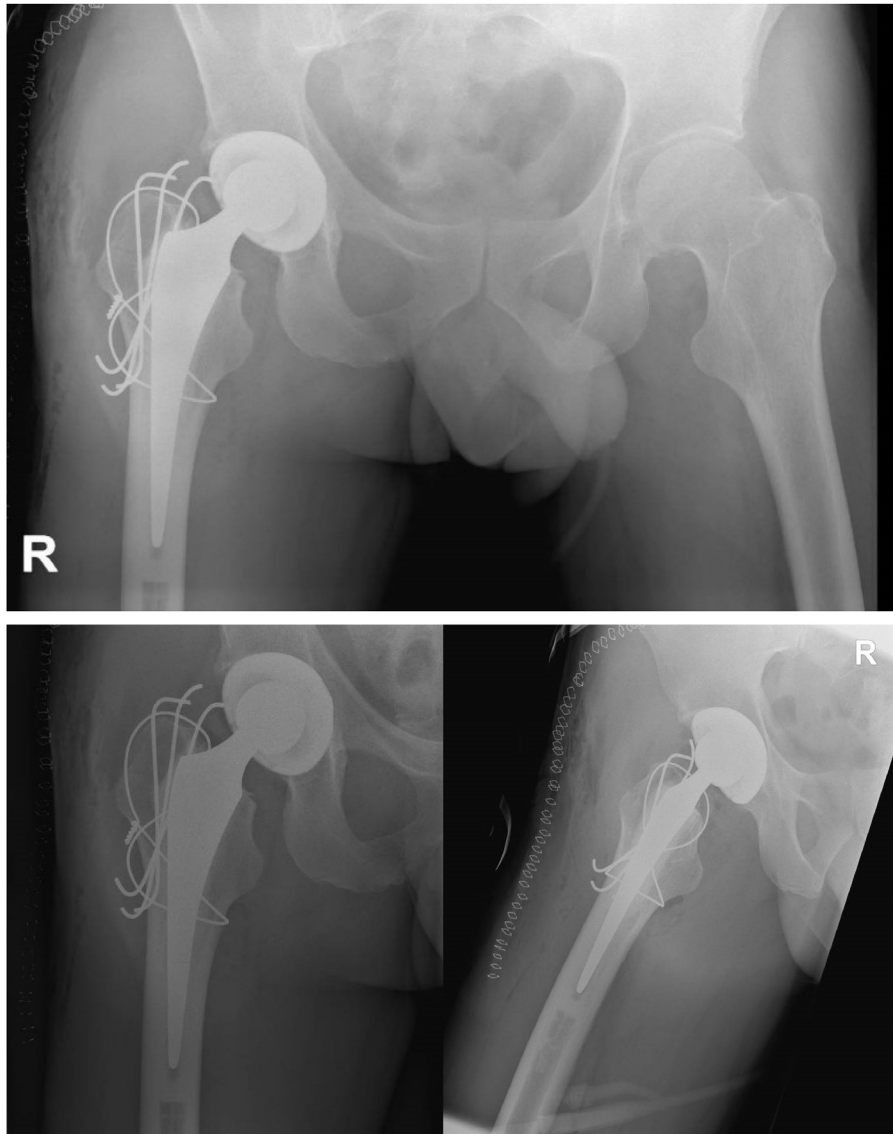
Postoperative radiographic imaging of pelvis and femur.
